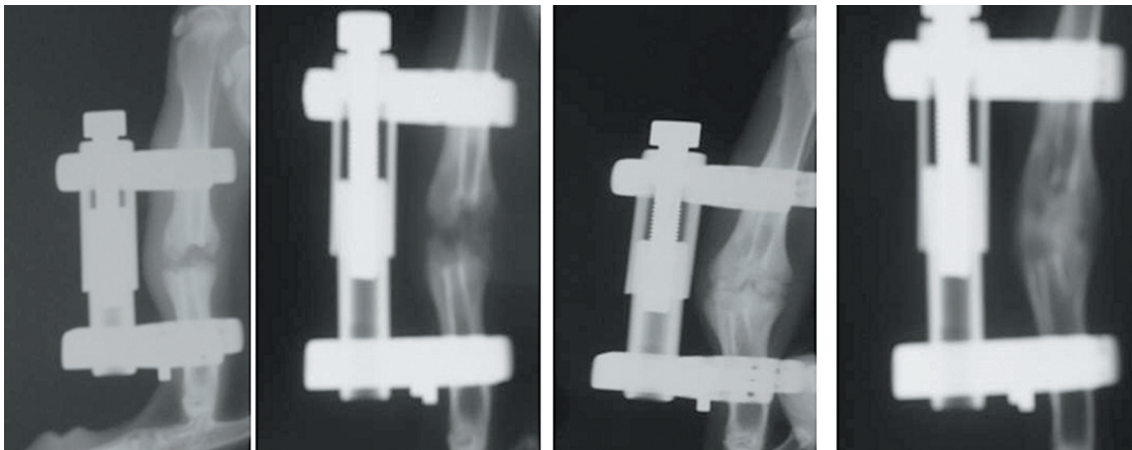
Serial radiographics shows the union of the bone.
